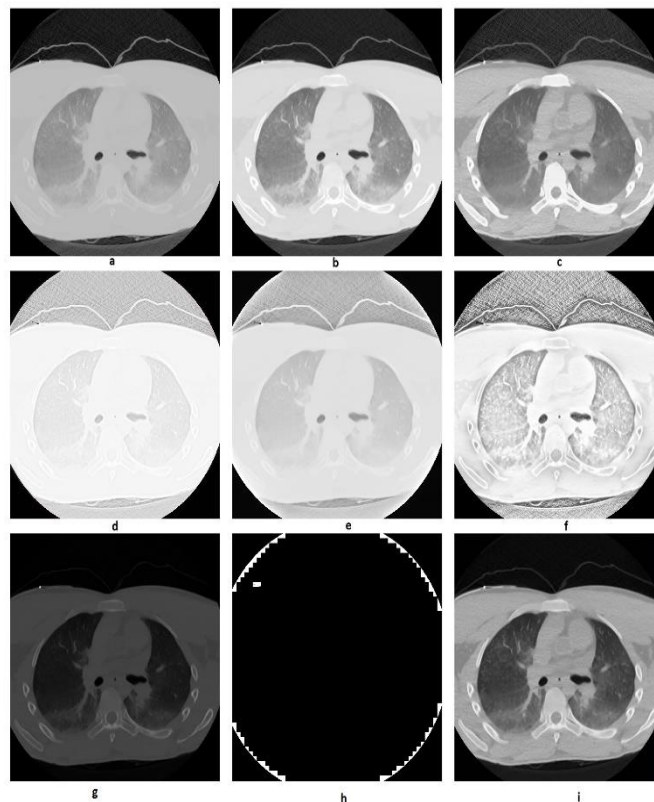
Enhanced test CT image of Chest by a) Reinhard (b) Kim (c) Khan (d) Li (e) Liang (f) Shibata (g) Al-Ameen (h) Gandhama l(i) Proposed, in the reading order.
